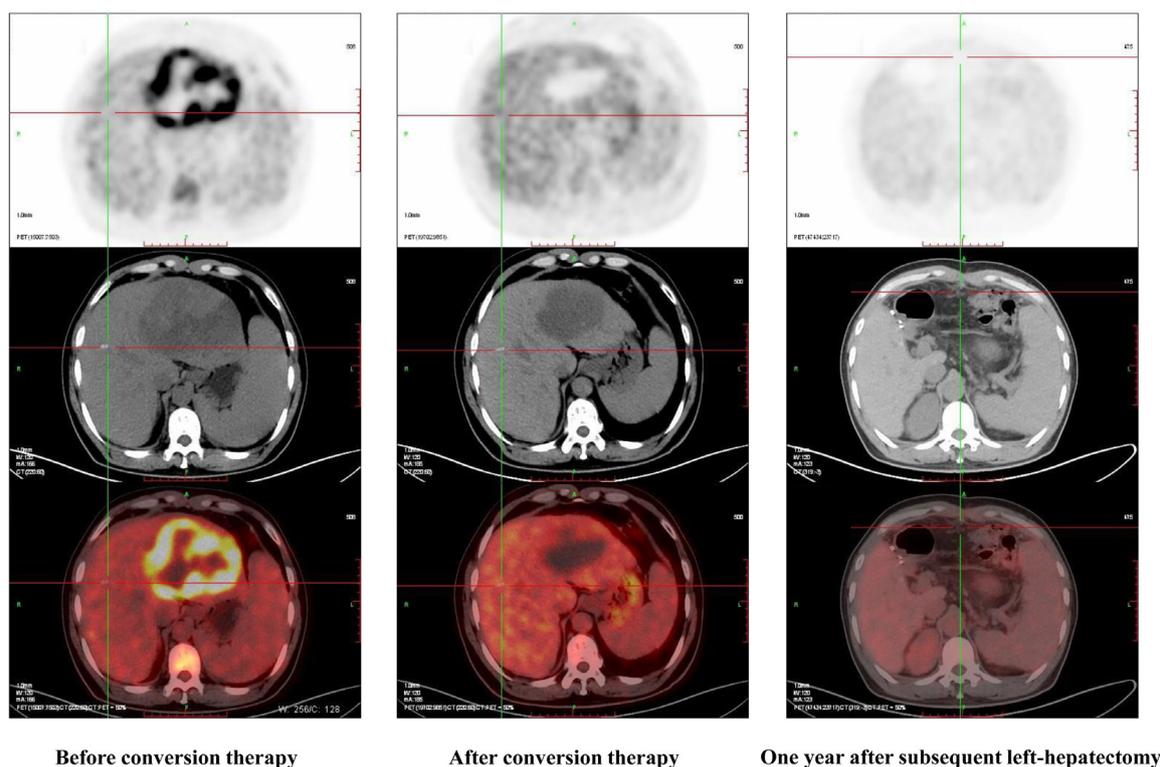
PET-CT assessment of conversion therapy followed by subsequent surgery. A patient in the current cohort who received conversion therapy followed by subsequent open left-hepatectomy. After 4 cycles of combination therapy with an ICI (sintilimab) and an AAD (lenvatinib) for 3 months, the standard uptake of the tumor decreased significantly. One year after subsequent left-hepatectomy, PET-CT revealed no signs of recurrence.
